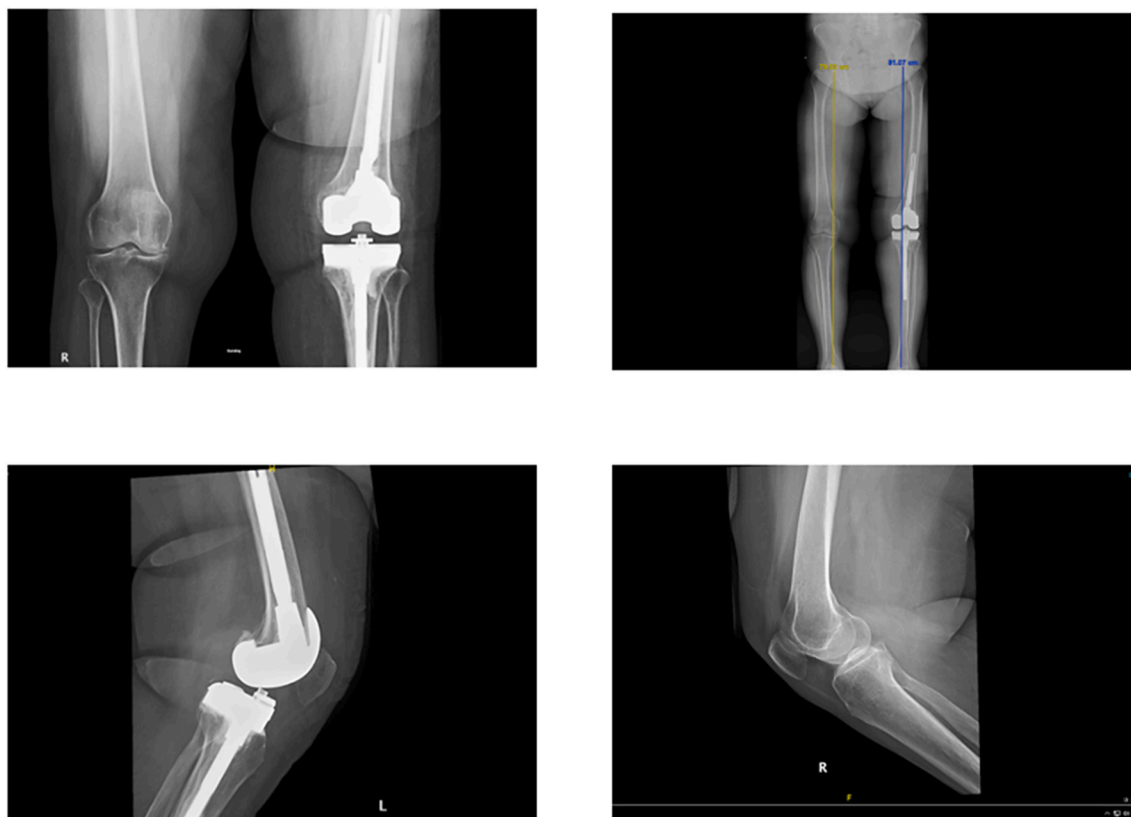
Bilateral knees standing AP and lateral and full-length standing radiographs 1 month post left knee revision arthroplasty.
